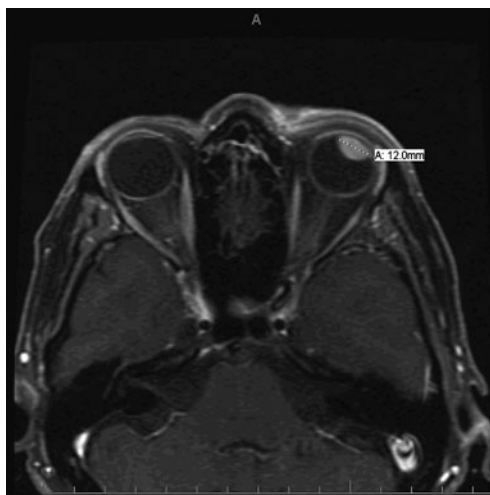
Magnetic resonance imaging showing an intraocular melanoma, left eye
